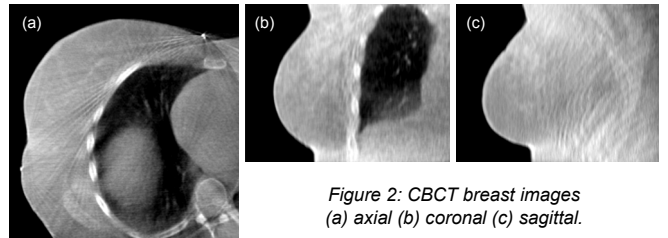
CBCT breast images (a) axial (b) coronal (c) sagittal.
